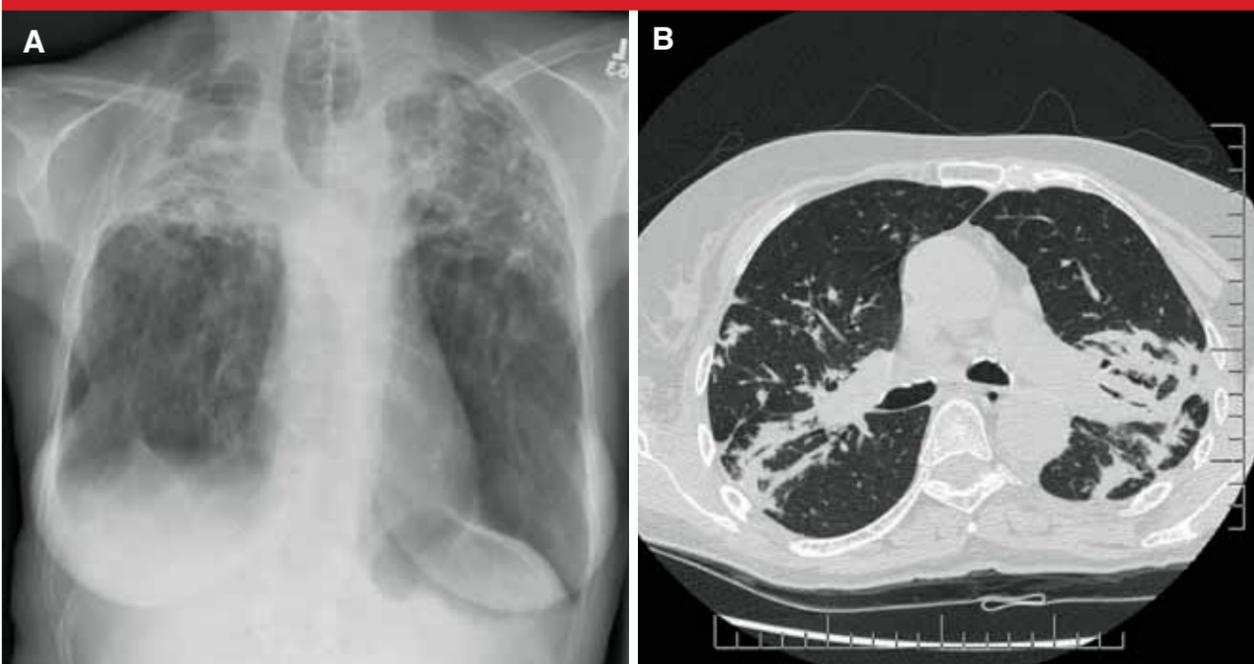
Stage IV pulmonary sarcoidosis on chest X-ray (A) and thoracic CT scan (B) with pulmonary fibrosis, predominantly upper lobe, with architectural distortion.
